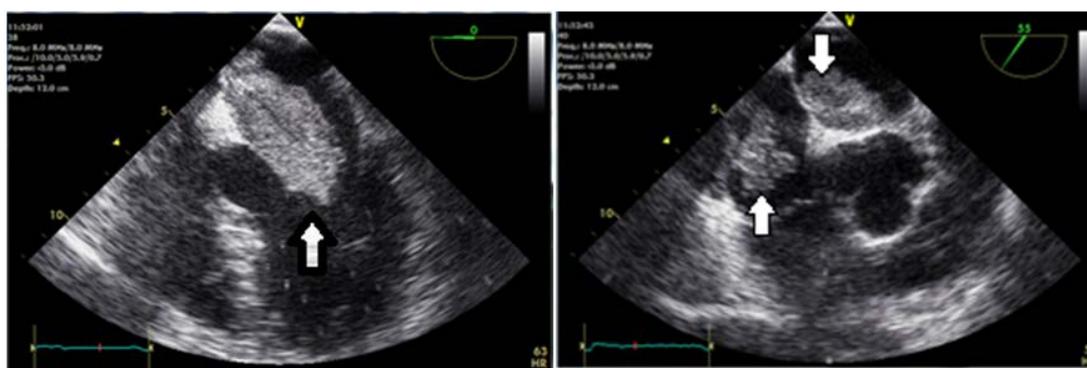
Transesophageal echocardiography showing left atrial tumor(left) and biatrial tumors(right)
